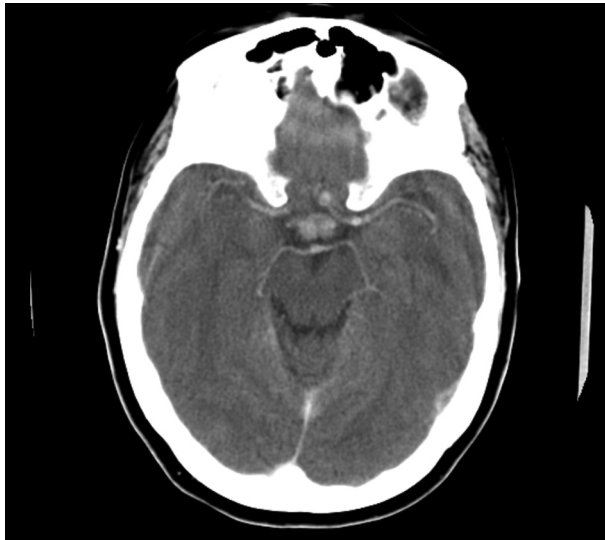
A suspicious enhancement in pituitary gland was found on CT after intravenous contrast injection
